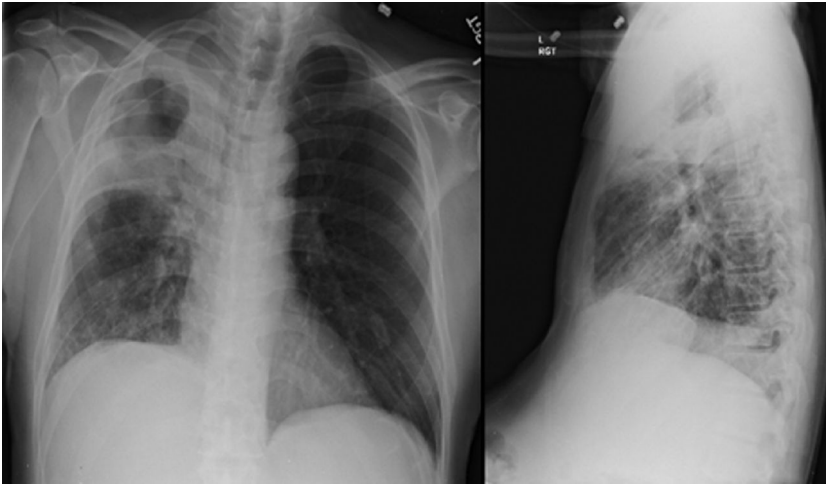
Posterioranterior and lateral chest radiographs demonstrating right upper lobe cavitory consolidation.
